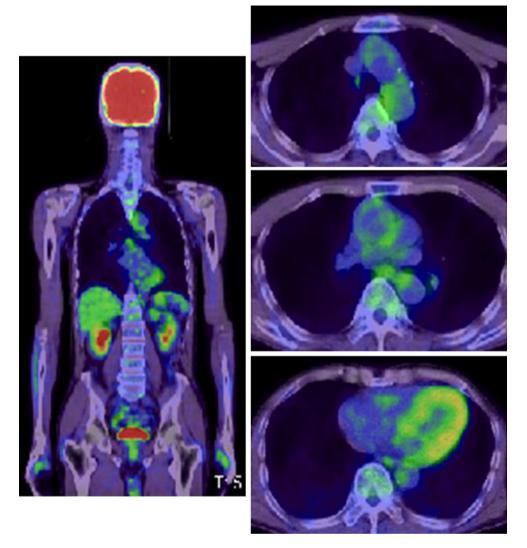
¹⁸FDG-PET/CT findings after the completion of eight courses of R-CHOP. Diffuse FDG uptake had completely disappeared in both lungs in the FDG-PET/CT findings after the completion of eight courses of R-CHOP
